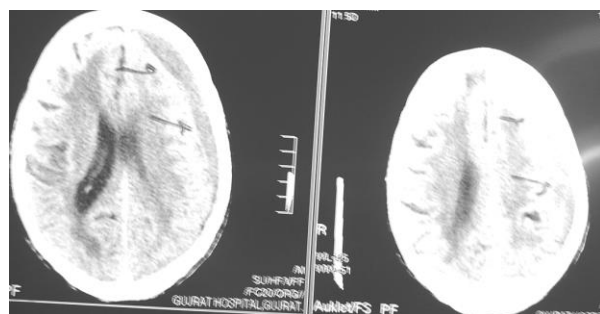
A: CT scan brain of 85 years old comatose patient with subdural hematoma
